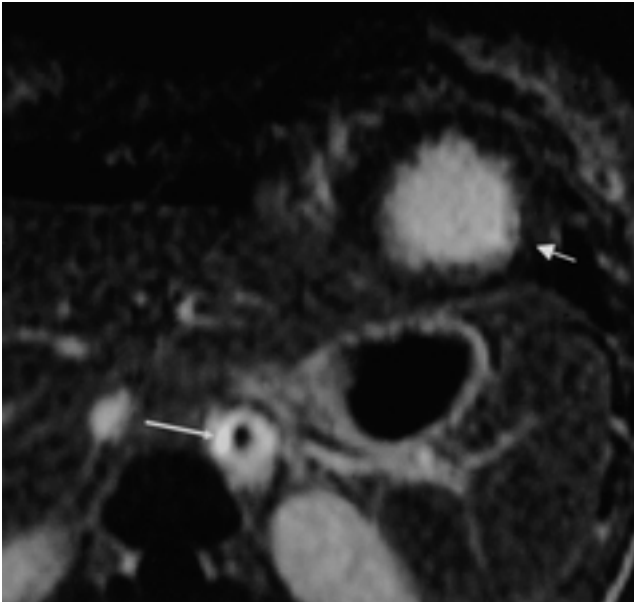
Chronic active TA (16-year-old female). Postcontrast breath-hold MR imaging shows contrast accumulation in the wall of proximal abdominal aorta (long arrow). This special, fast SPGR-EPI hybrid sequence was originally designed for myocardial infarction imaging. The signal intensity of the normal myocardium (short arrow) is much lower than that of the aortic wall. Also note luminal stenosis of the aorta.
